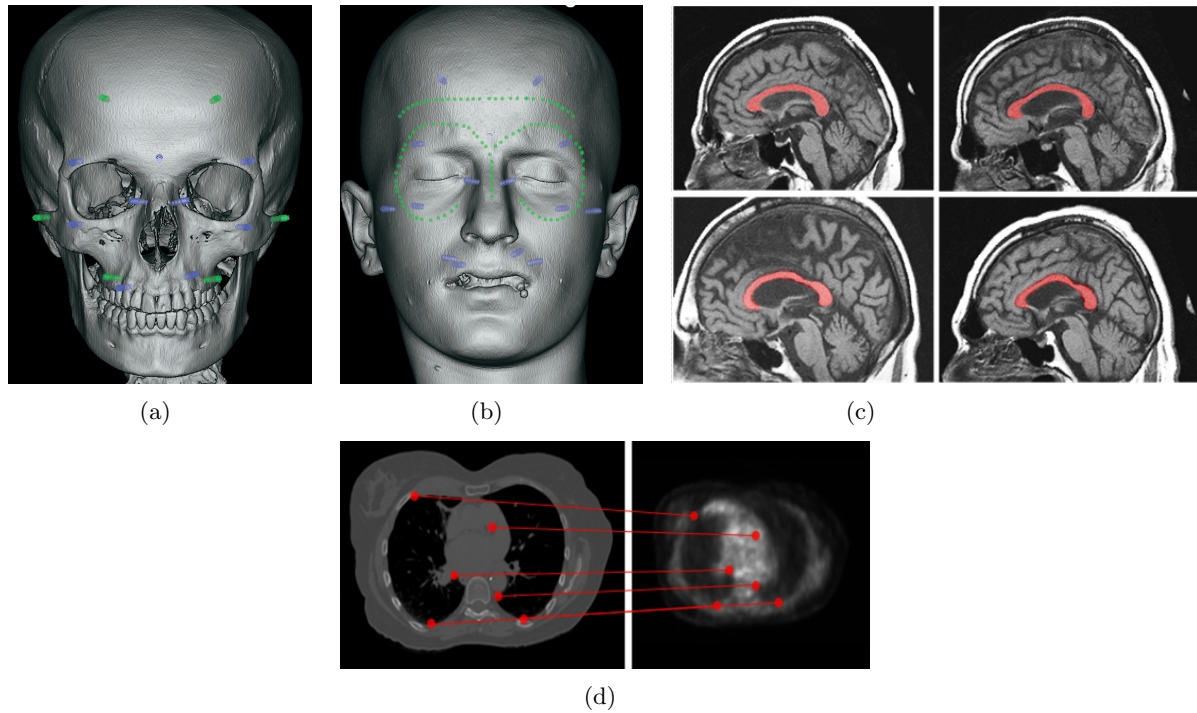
Examples of different landmarks used in medical image registration [8]. Screws are used as invasive markers as shown in (a). Cutaneous landmarks can also be used as non-invasive markers (b). Anatomical structures, present in the source and target images, can be also used as landmarks, given a previous segmentation of such structures (c) as shown in this MR example. User defined or geometrical landmarks are also used (d) as in this CT-PET registration example.
